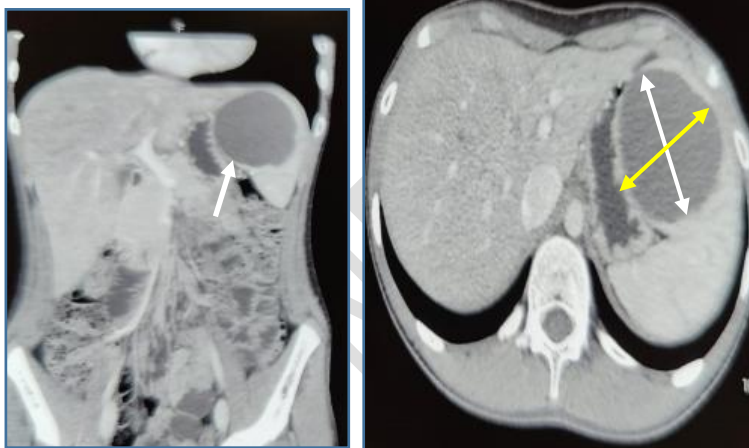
CT abdomen showing large primary splenic cyst at upper pole. Measuring 8x7x6 cm
